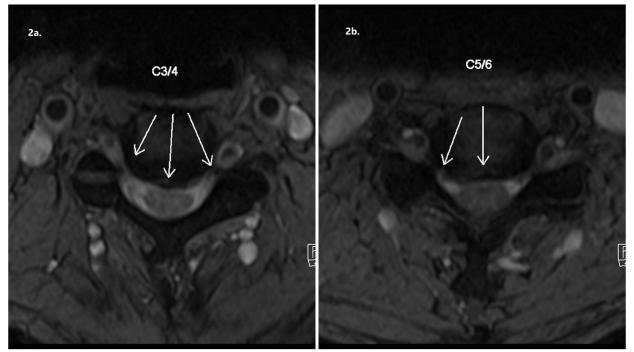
Transverse view of cervical plain magnetic resonance imaging reveals circumferential disc bulge at C3/4 (a) and C5/6 (b).
